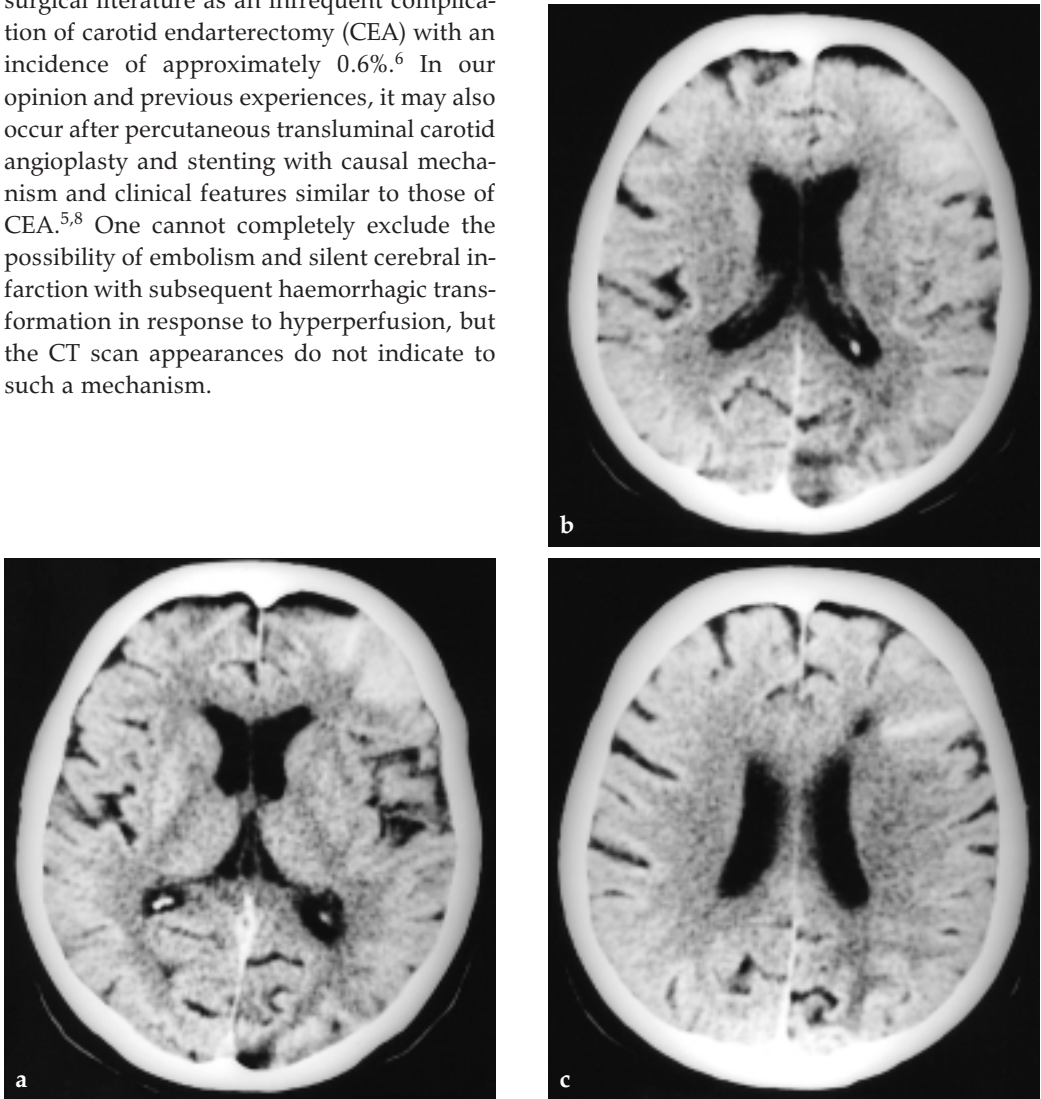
CT of the brain demonstrates small haemorrhage in the left frontal region.
